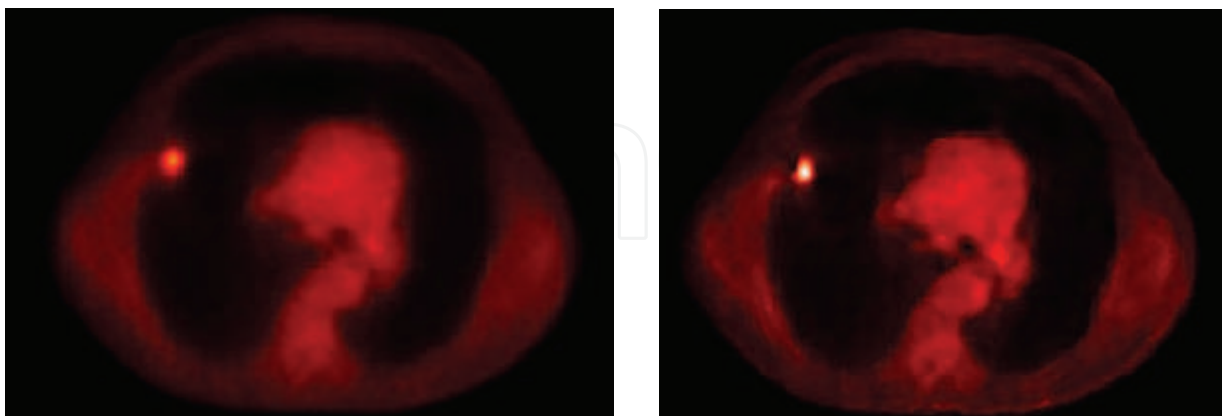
Original PET image before (left) and after (right) fusion with a corresponding CT image, by using a local model instead of a global one.
